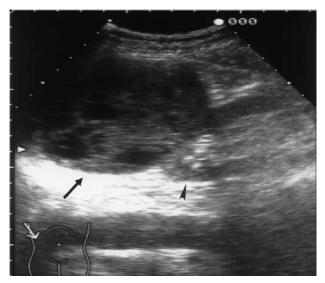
Ultrasonography demonstrated a renal mass with a solid component (arrow) in the right kidney (arrowhead).
